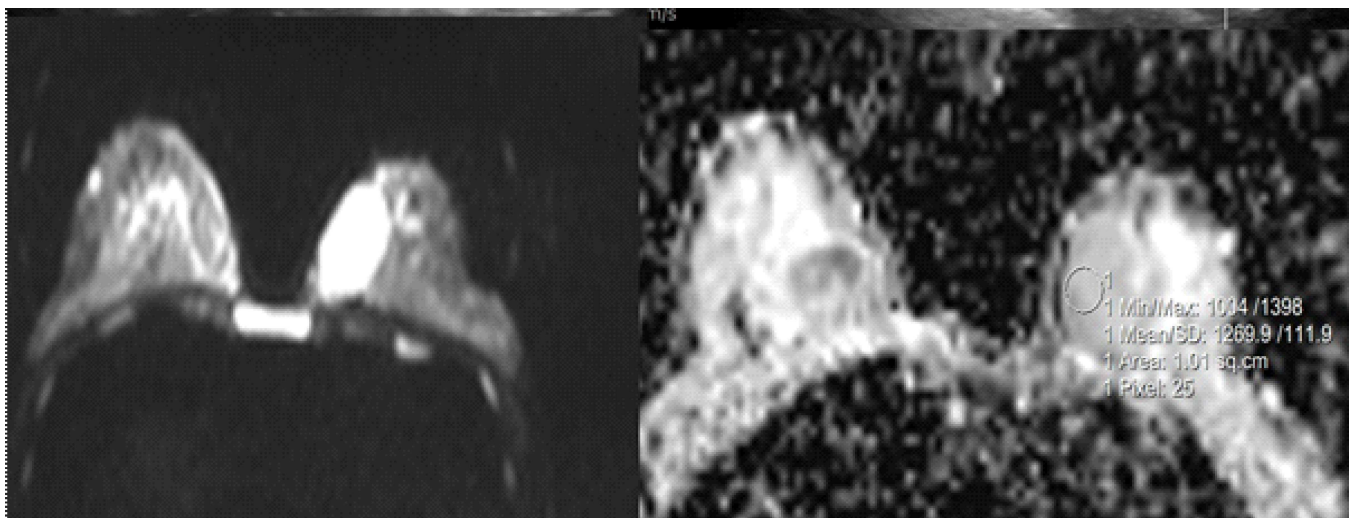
MRI diffusion-weighted and corresponding ADC image shows ADC - value of $1.26 \times 10^{-3} \text{ mm}^2/\text{s}$. FNAC report of the lesion was Fibroadenoma.
